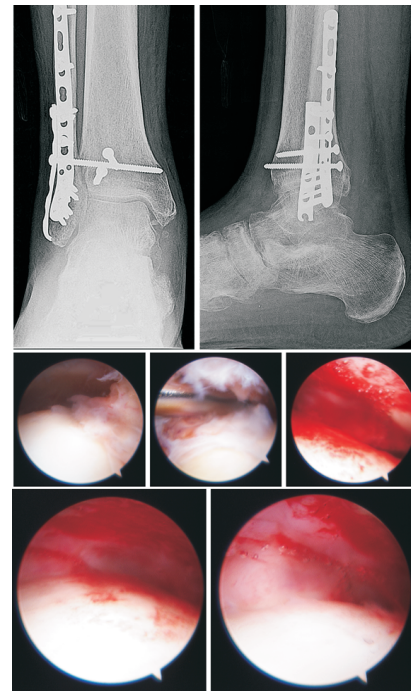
Eight month postoperative anteroposterior and lateral radiographs with second look arthroscopy of a bimalleolar equivalent ankle fracture following a motor vehicle collision that underwent surgical repair with evidence of significant arthrofibrosis and residual chondral injury.
